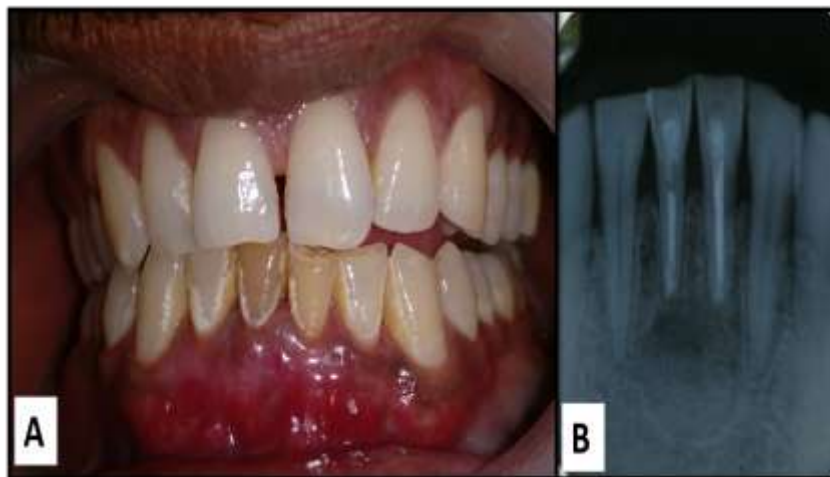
a) 1 month follow up photograph, b) 3 month follow up radiograph
